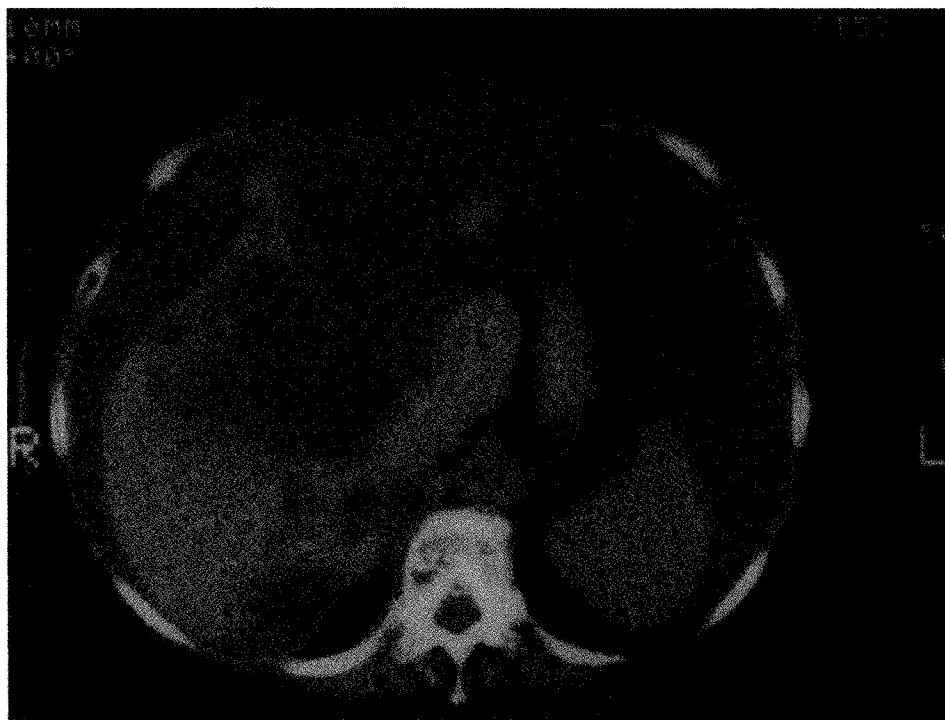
CT scan showing caudate lobe hypertrophy (CL).
